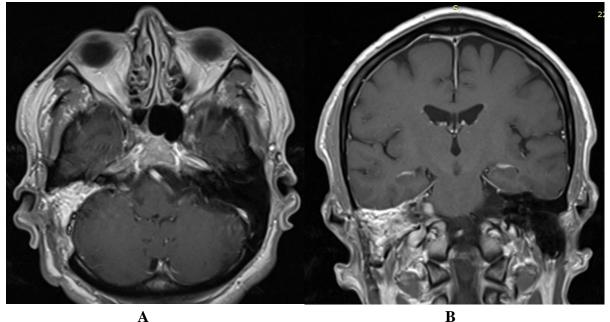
MRI images with CPA visualization at 1 year postoperatively C - axial projection; D - coronal projection.
